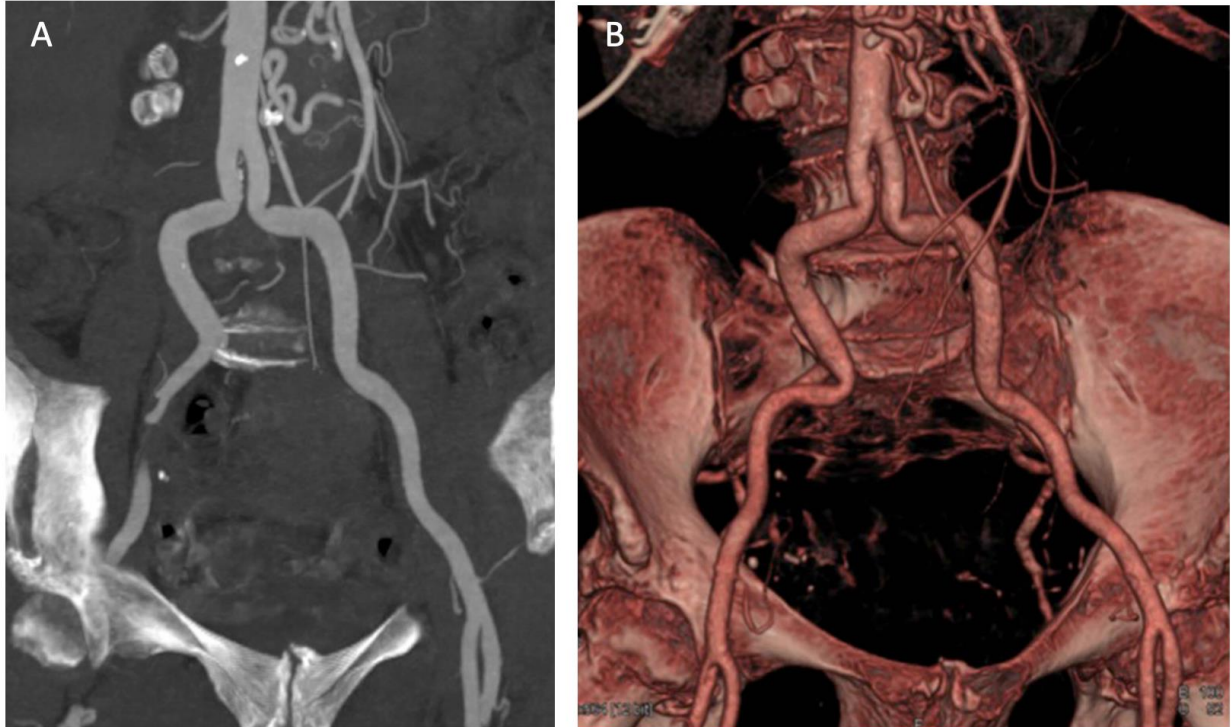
A) Multiplanar reconstruction showing minimal calcification of the peripheral vessels. B) a 3D reconstruction of the same patient showing severe kinking of the ileo-femoral access. (Reused with permission from Springer Nature publishing. Mohamed Marwan et al, Role of Cardiac CT Before Transcatheter Aortic Valve Implantation (TAVI). *Curr Cardiol Rep.* 2016 Feb;18(2):21. doi: 10.1007/s11886-015-0696-3)⁴³.
